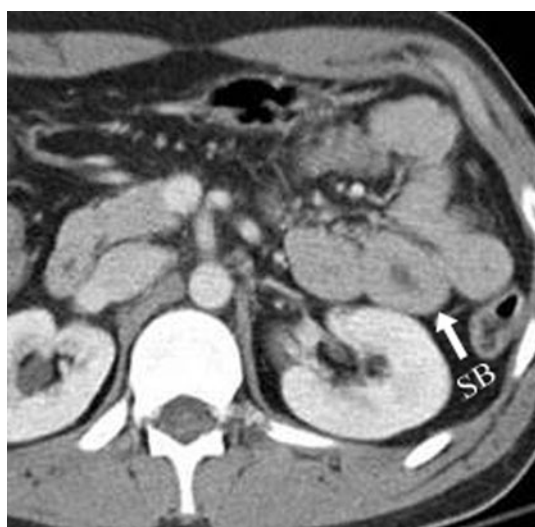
A 21-year-old male status post-blunt abdominal trauma. Axial contrast-enhanced CT of the abdomen demonstrated a loop of small bowel (SB) with apparent wall thickening. Chart review revealed that the patient did not have bowel injury. This finding was due to incomplete mixing of oral contrast material and bowel contents.
